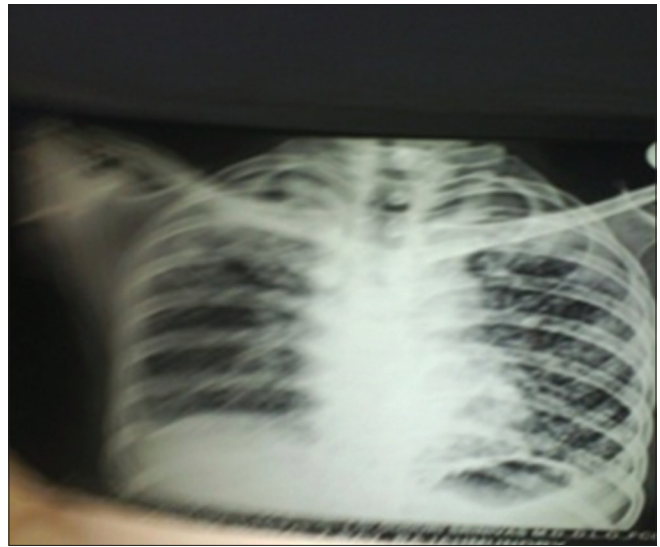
Chest X-ray: Bilateral multiple military mottling
